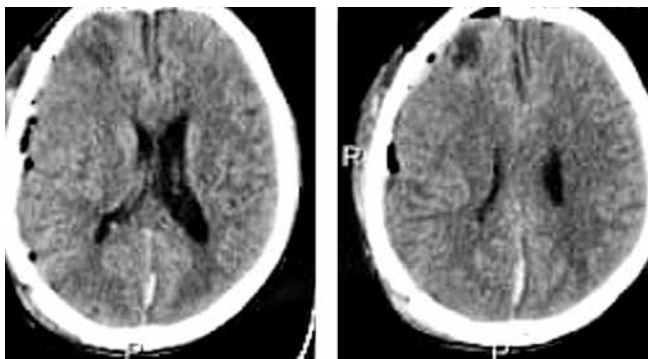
Postoperative CT head axial cut showing decrease in midline shift, air pockets in subdural region and no collection
